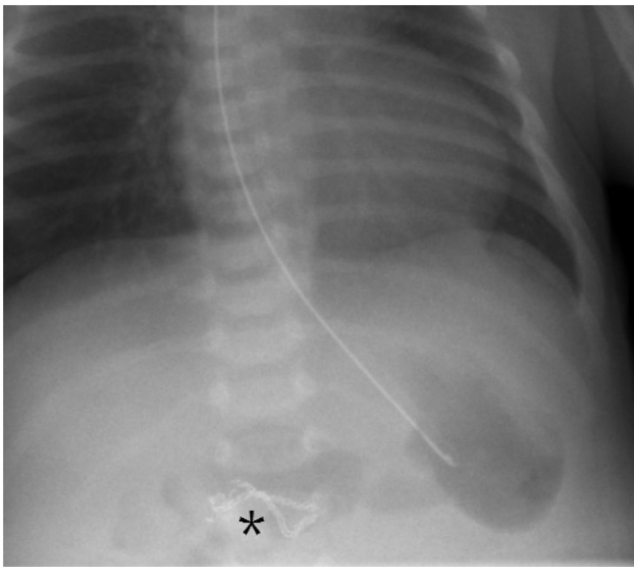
Postoperative plain radiograph showing the staple line (*) in the duodenum.
